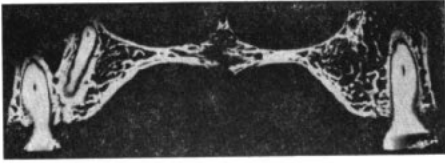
Soft x-ray radiographs showing gross lack of mineralization in midline of palate.
